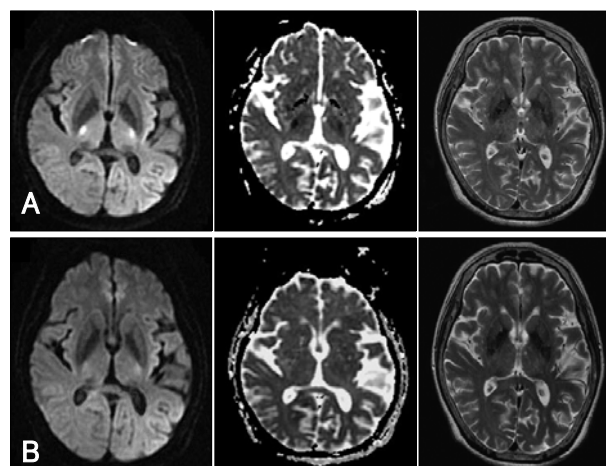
DWI, ADC, and T2 weighted MRI. A: On admission, focal nodular bright signal intensities in bilateral posterior limb of the internal capsule on DWI, and corresponding decreased signal intensities on ADC image. B: 24 hours after admission, DWI and ADC changes returned to normal. DWI: diffusion weighted images, ADC: apparent diffusion coefficient.
